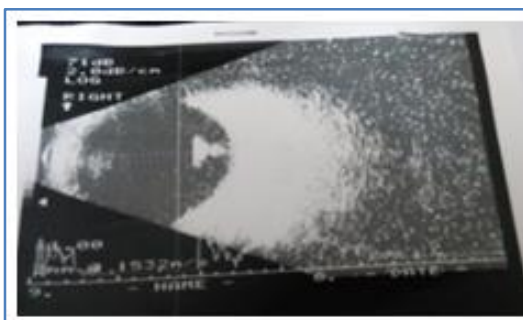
Ultrasonography of the Globe Shows Staphyloma Intra Ocular Foreign Body
